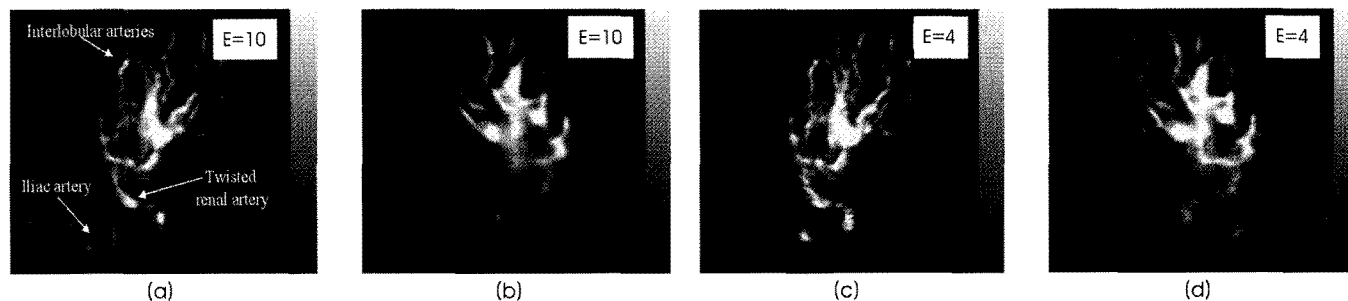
Rendered color Doppler images with the power estimates obtained from the kidney transplant patient by applying the AC-ACR when (a)  $E=10$  and (b)  $E=10$  for two different viewing angles.
